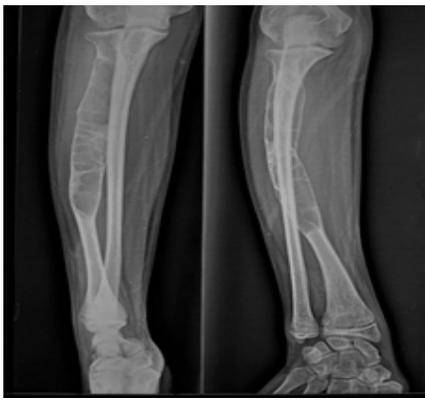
Skeletal radiograph (frontal and lateral views) showing an expansile lytic lesion with ground glass appearance involving the proximal meta-diaphysis of the right radius, with its resultant bowing.
